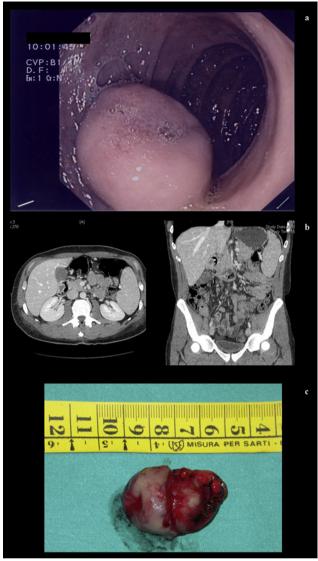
Duodenal GIST of the first portion. a. Endoscopy; b. contrastenhanced abdominal CT scan; c. Wedge duodenal resection with primary suture
